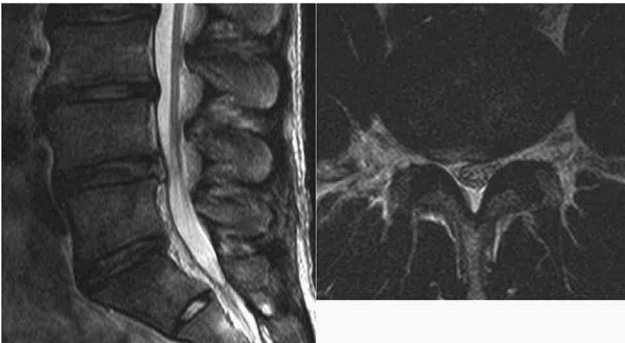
MRI (T2-weighted sagittal and axial view at L4/5 level) after the initial PED. The HNP was removed by PED using the transforaminal approach.
